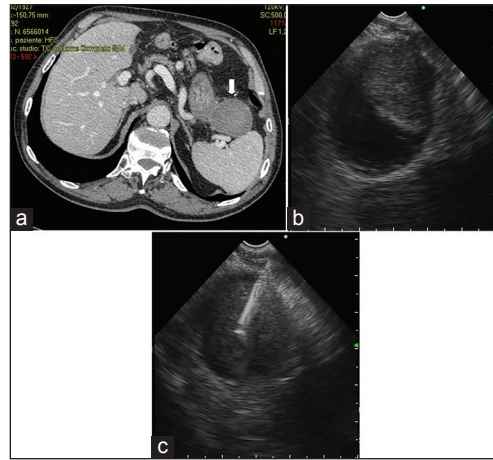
(a) Computed tomography shows a hypodense mass (arrow) between the gastric stump and the spleen (b) FV EUS shows a hypoechoic oval mass external to the gastrointestinal wall (c) FV EUS-FNA is performed with a 22-gauge needle. Cytology showed hemangiopericytoma
